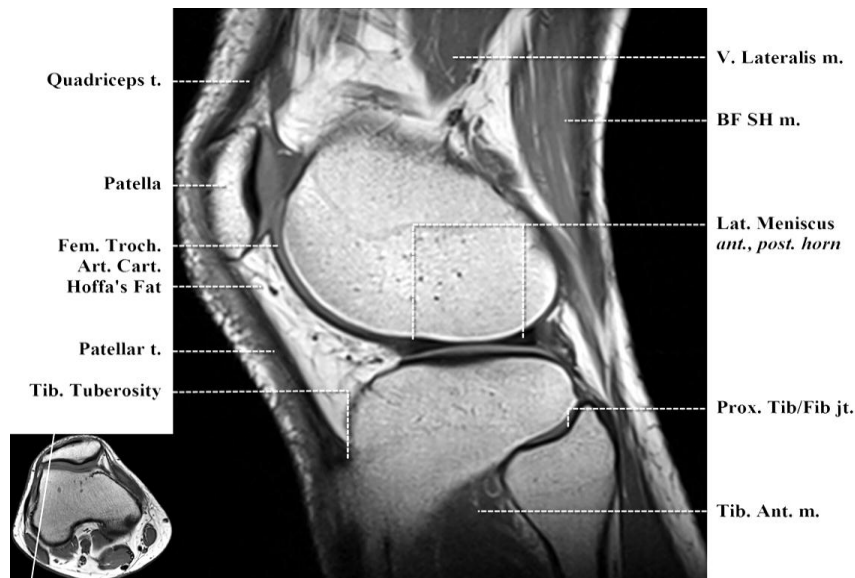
Sagittal T1-weighted image. Lateral femorotibial compartment. ant., anterior; Art.Cart., articular cartilage; BF SH, biceps femoris short head; Fem. Troch., femoral trochlear; m., muscle; Lat., lateral; post., posterior; Prox. Tib/Fib jt., proximal tibiofibular joint; Tib., tibia; Tib. Ant., tibialis anterior; t., tendon; V., vastus *Quoted from (Vohra et al., 2011)*.
